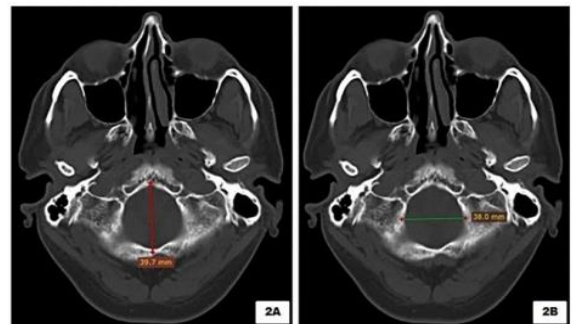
Computed tomography scan - axial view shows length (fig. 2A) and width (fig. 2B) of foramen magnum.
